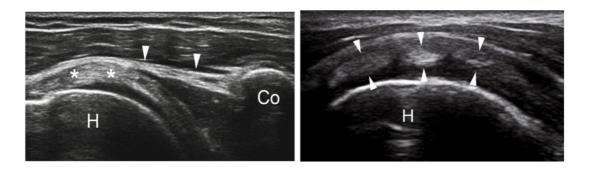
Sample of shoulder joints under ultrasound [adapted from (Silvestri, Muda, & Sconfienza, 2012)]
